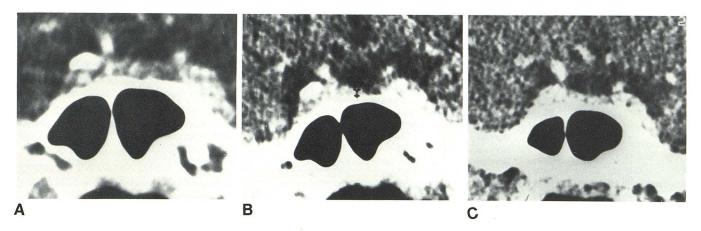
Case 3. Moderate degree of progressive pituitary atrophy. A, First CT (normal pituitary). B, Second CT (mild atrophy). C, Third CT (moderate atrophy). Small cystic low density within left side of enhanced sellar area on C is an artifact.
